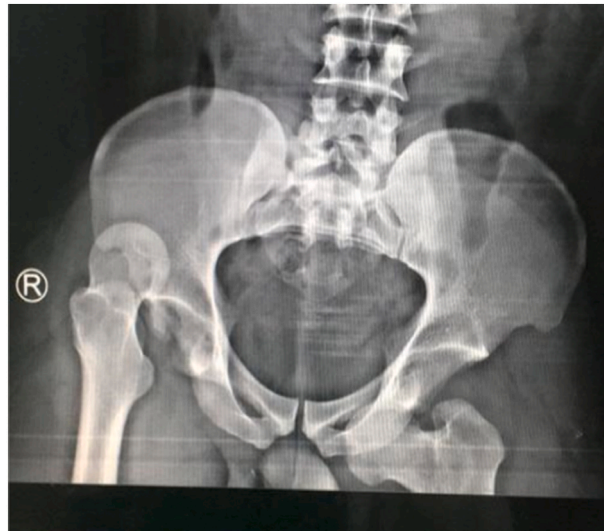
A: X-rays showing asymmetric hip dislocation; right posterior superior, and left anterior inferior. B: CT scans showing Obturator type Epstein IIA anterior left hip dislocation and Thompson-Epstein III posterior superior right hip dislocation.
